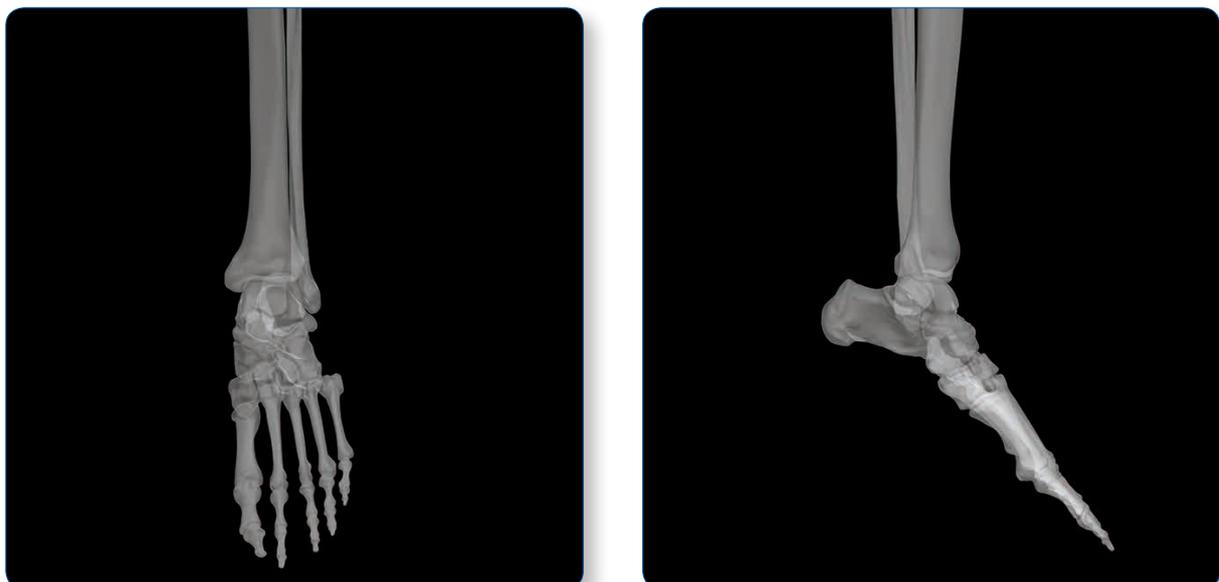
AP view (a) and ML view (b) radiographs of an Equinus foot
